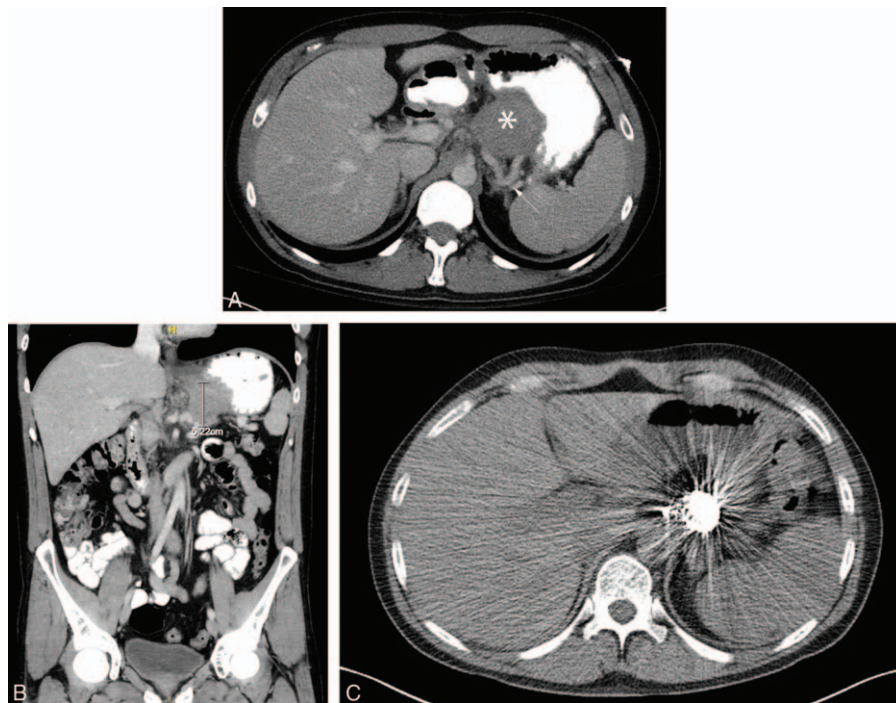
(A) Axial view of abdominal CT, with IV contrast, shows a 5.2 cm pancreatic/peripancreatic mass (labeled*) compressing the stomach (which has a radiopaque penumbra due to orally ingested contrast) along the lesser curve, and shows that this mass causes a kink (arrow) that partially obstructs the splenic vein and causes sinistral portal hypertension. (B) Coronal view of abdominal CT, with IV contrast, shows a 5.22 cm pancreatic/peripancreatic mass extending superiorly and compressing the stomach, with a radiopaque penumbra due to orally ingested contrast along the lesser curve, and extending inferiorly to the pancreas. (C) CTA 8 weeks after angiographic embolization of left gastric artery demonstrates the pseudoaneurysm has markedly decreased in size, contains metallic coils (producing a metal streak artifact), and has no blood flow. Occlusion of the pseudoaneurysm reverses the splenic vein compression and relieves the sinistral portal hypertension responsible for bleeding from portal hypertensive gastropathy. CT = computerized tomography, CTA = computerized tomographic angiography, IV = intravenous.
